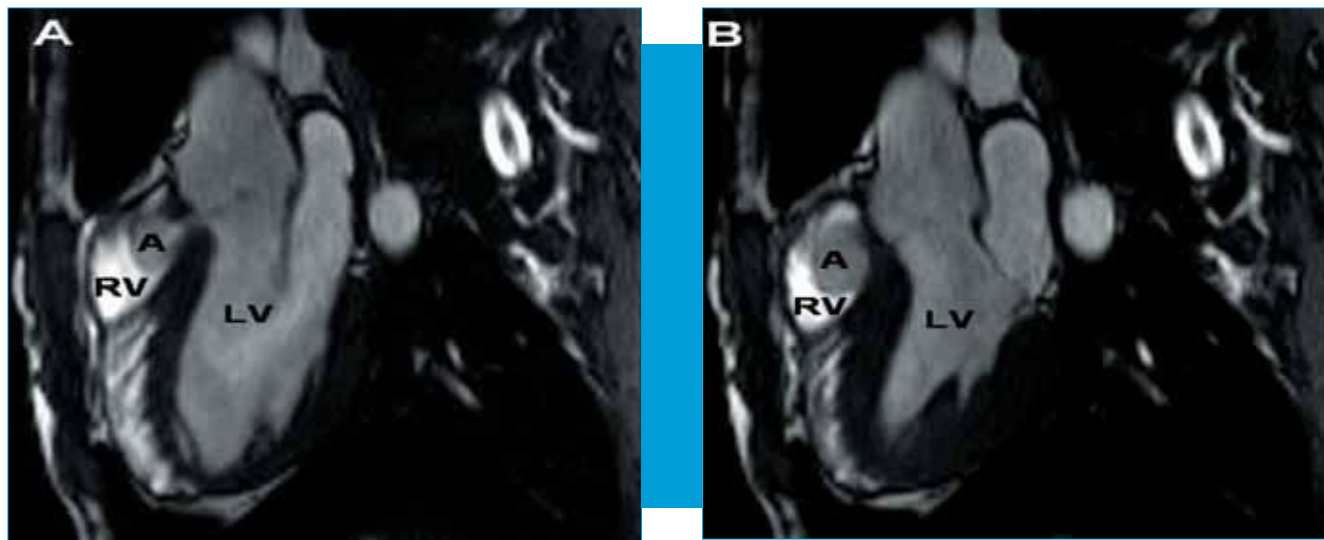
Cardiac magnetic resonance (Cine MRI 3-chamber view) revealed small membranous ventricular septal defect (A) and sack-like aneurysm protruding into the right ventricle without signs of outflow tract obstruction (B).
